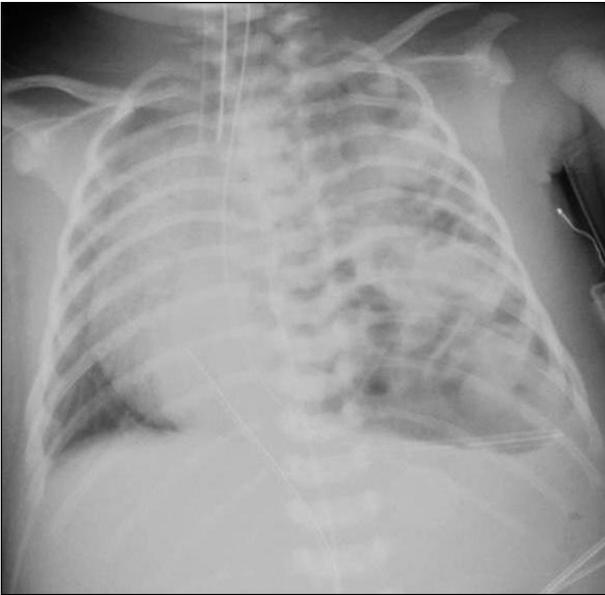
Neonatal chest radiograph showing left-sided CDH. Multiple gas-filled loops are present within the left hemithorax, and mediastinal and cardiac shift to the right is evident. The infant has umbilical arterial and venous lines in place along with endotracheal and orogastric tubes.
